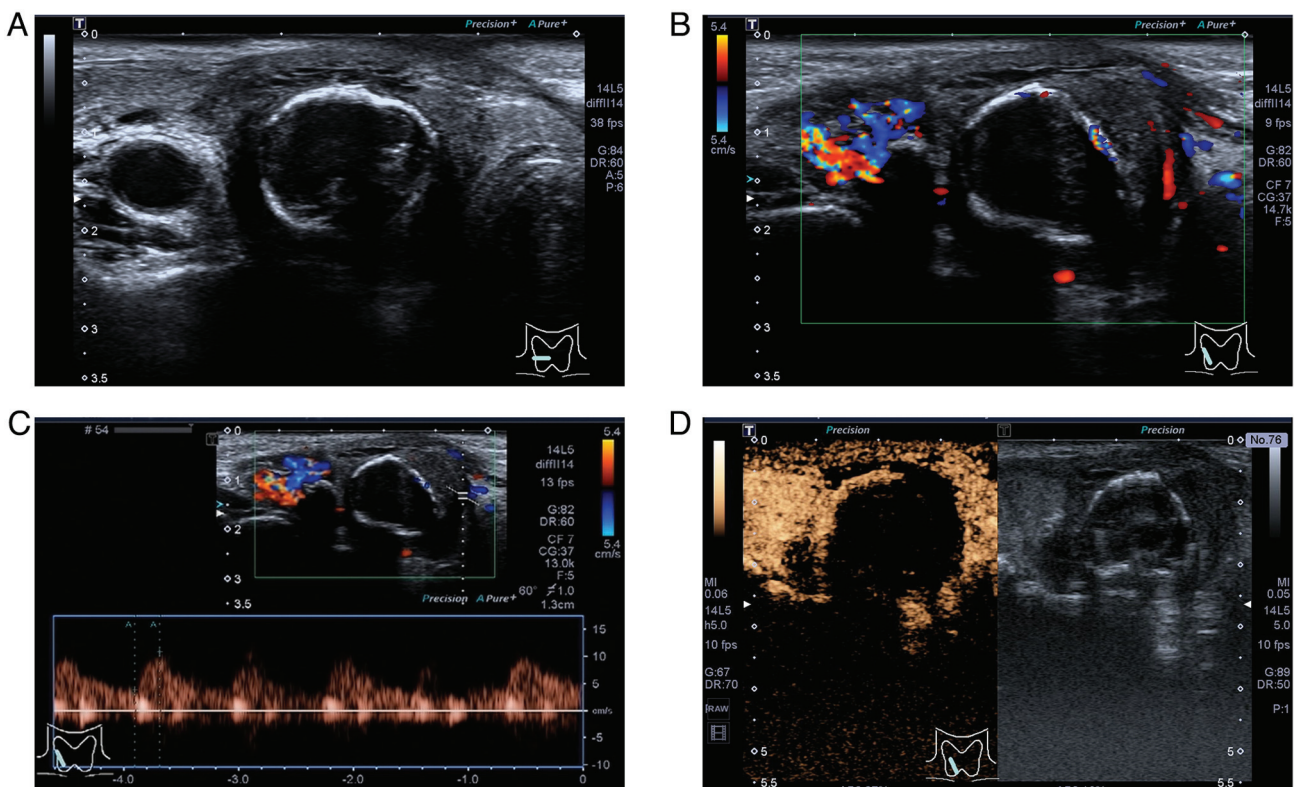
Combined US and CEUS findings of Lesion A after treatment. (A) US revealed that the size had significantly reduced. (B) Color Doppler flow imaging showed abundant blood flow signals inside. (C) The resistive index value was decreased to 0.65. (D) CEUS findings revealed that the percentage of non-enhancing areas within the nodule was higher than the percentage before treatment. US, ultrasound; CEUS, contrast-enhanced US.
